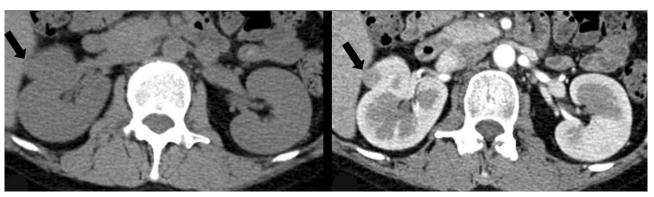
Computed tomography revealed a solid, well-circumscribed lesion in the right kidney. Left, The mass was not delineated on a pre-enhanced scan. Right, The mass was moderately enhanced on an enhanced scan.
